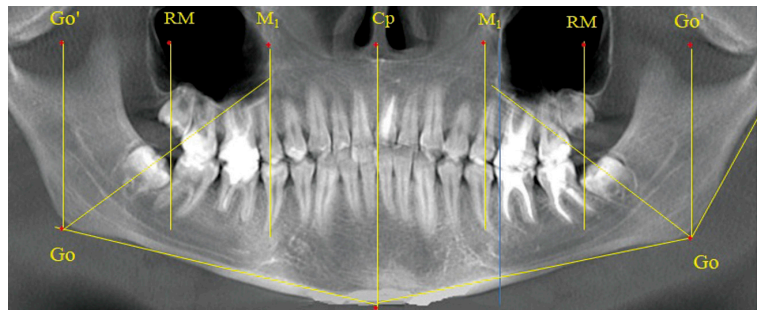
Radiograph of a 12-year-old child after replacement of primary teeth with permanent dentition
